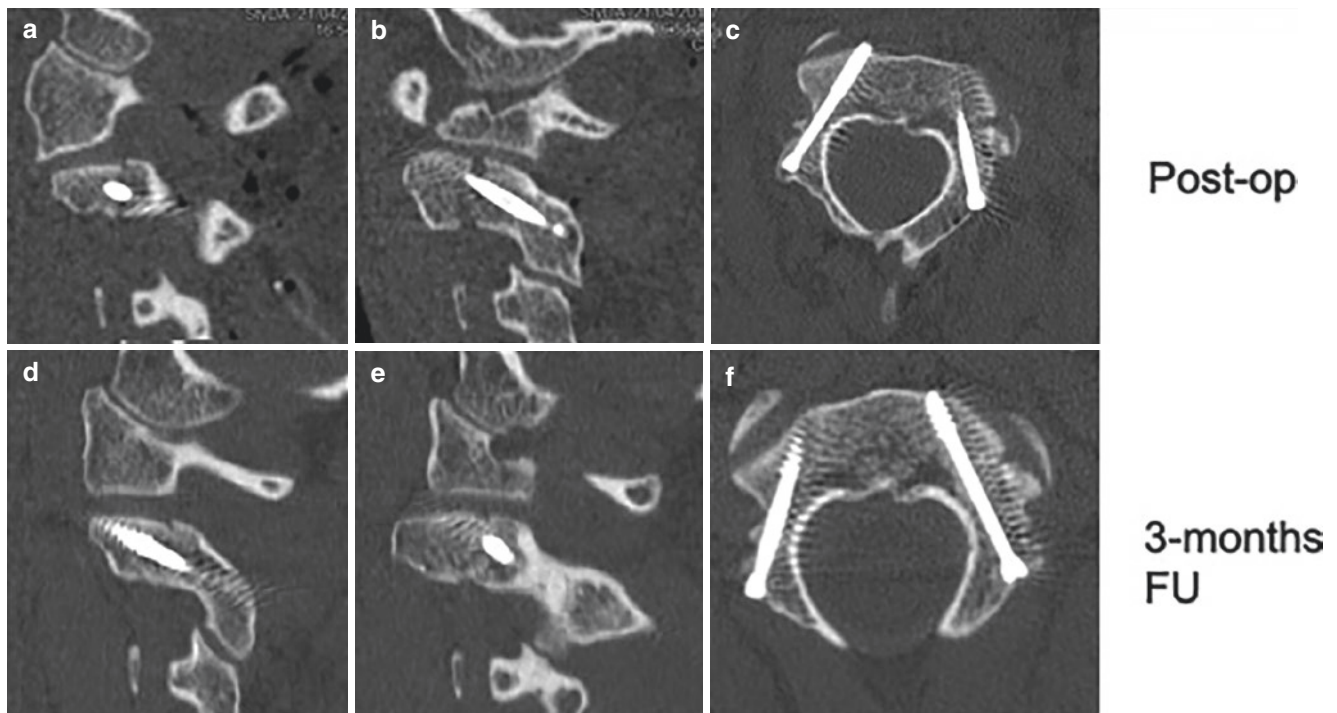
Postoperative CT-scan showing a satisfactory screw's positioning also documenting the reduction of fracture, immediately after surgery (a–c) and at 3-months (d–f); a solid osseous fusion of both pedicle is documented by sagittal views (d, e) 3 months after surgery
